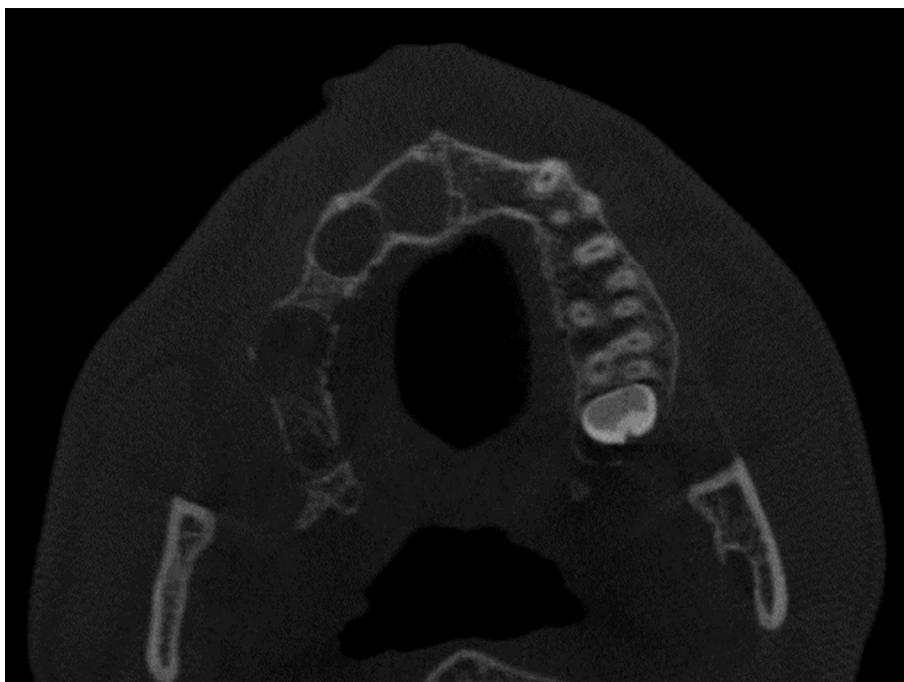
CBCT axial slice of a patient with NBCSS. Note 3 lesions that are localized at the same quadrant that did not cause significant expansion.
